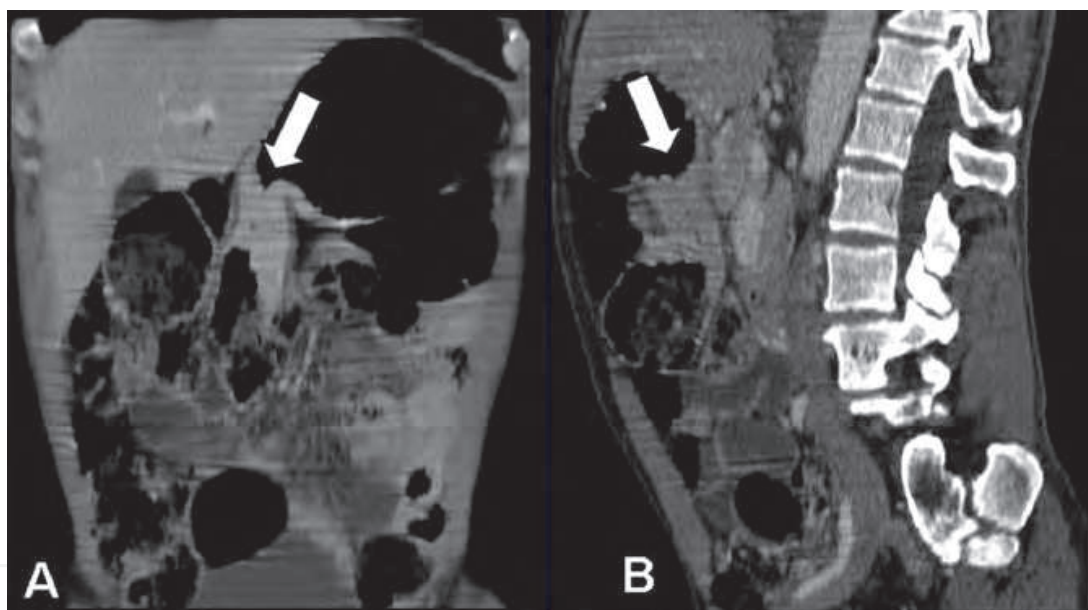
Gastric carcinoma. A. CT Coronal Reconstruction. B. CT Sagittal Reconstruction. The tumor appears as an irregular wall thickening (arrows).
